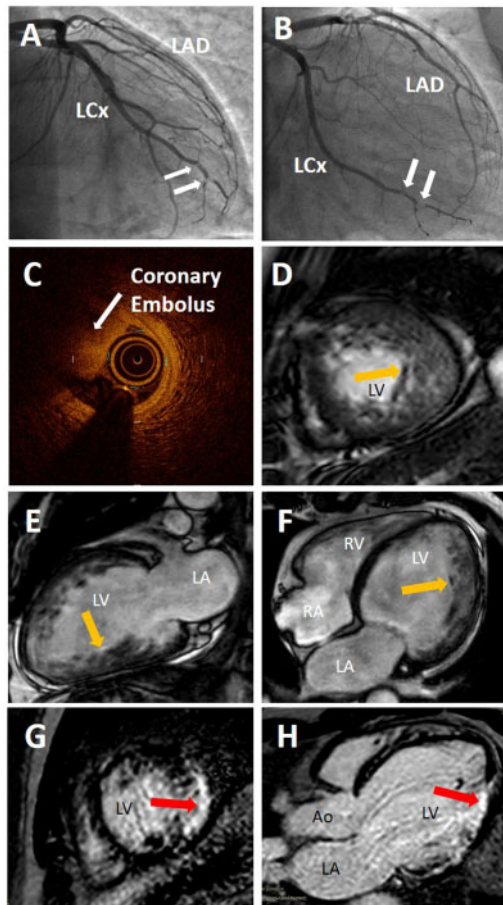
Anteroposterior (A) and right anterior oblique caudal (B) views of coronary angiography showing two filling defects (suggestive of thrombus, marked by white arrows) in first obtuse marginal branch of left circumflex artery. Optical coherence tomography showing coronary thrombus (C, white arrow). Non-compacted myocardium (marked by yellow arrows) seen on cardiac MRI in short axis (D), two-chamber (E), and four-chamber (F) views. Cardiac magnetic resonance imaging demonstrated transmurular late gadolinium enhancement (marked by red arrows) consistent with myocardial infarction of the mid-lateral wall, shown in short axis (G) and left ventricular outflow tract (H) views. Ao, aorta; AP, anteroposterior; LA, left atrium; LAD, left anterior descending artery; LCX, left circumflex artery; LGE, late gadolinium enhancement; LV, left ventricle; MRI, magnetic resonance imaging; RA, right atrium; RAO, right anterior oblique; RV, right ventricle.
